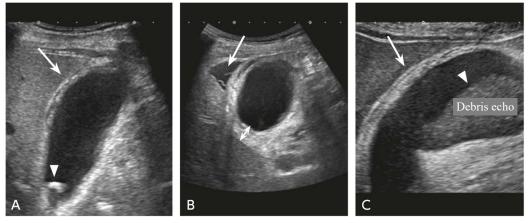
Figure Acute cholecystitis (ultrasound appearance)
